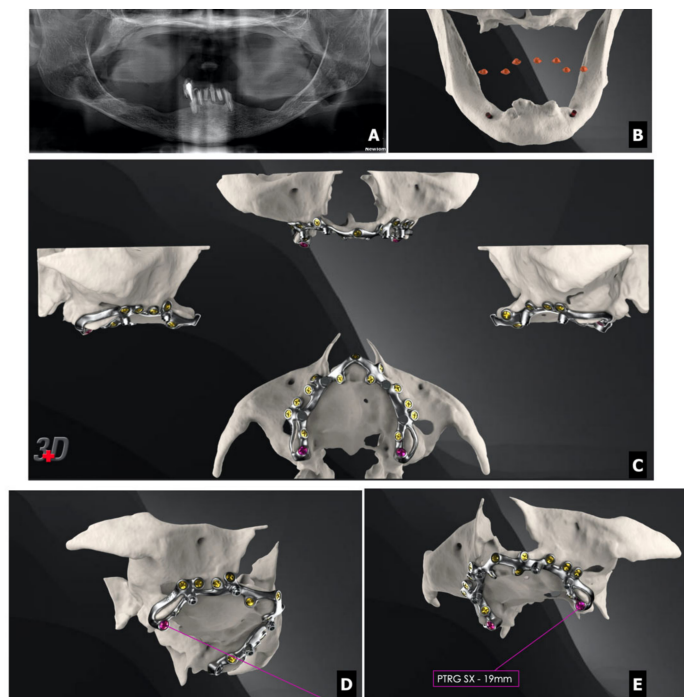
(A) Pre-op panoramic radiograph of an atrophic patient treated with a custom subperiosteal implant. (B) Three-dimensional reconstruction of the edentulous ridges. (C) 360° view of the custom implant framework design. (D) Detail of the left pterygoid fixation. (E) Detail of the right pterygoid fixation.
